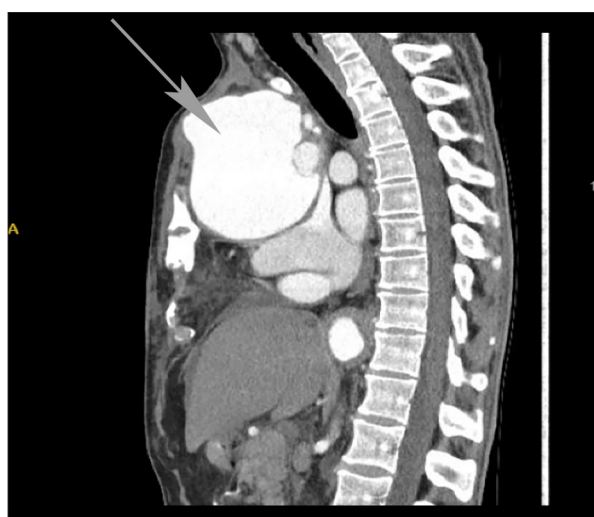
Computed tomography angiography (sagittal view) showing a large pseudoaneurysm arising between the ascending aorta and the sternum, with pronounced bulging through the sternal defect (arrow).
